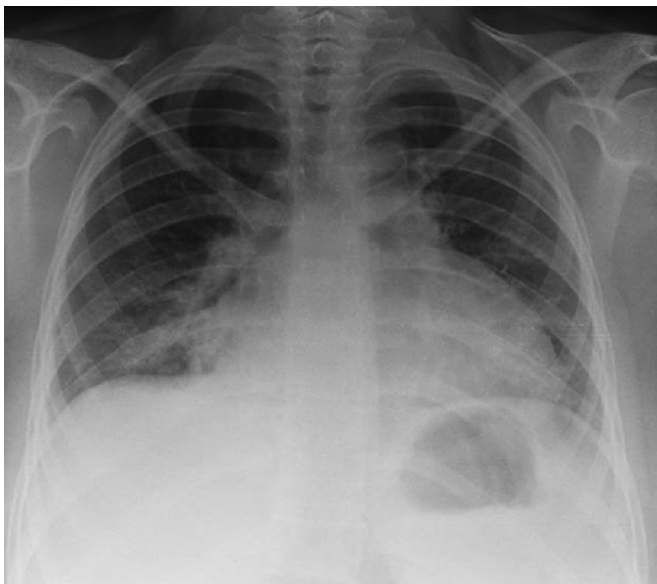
Chest radiograph showing enlarged cardiac silhouette in a patient with systemic arthritis and pericarditis. Adapted from the personal collection of the authors.
